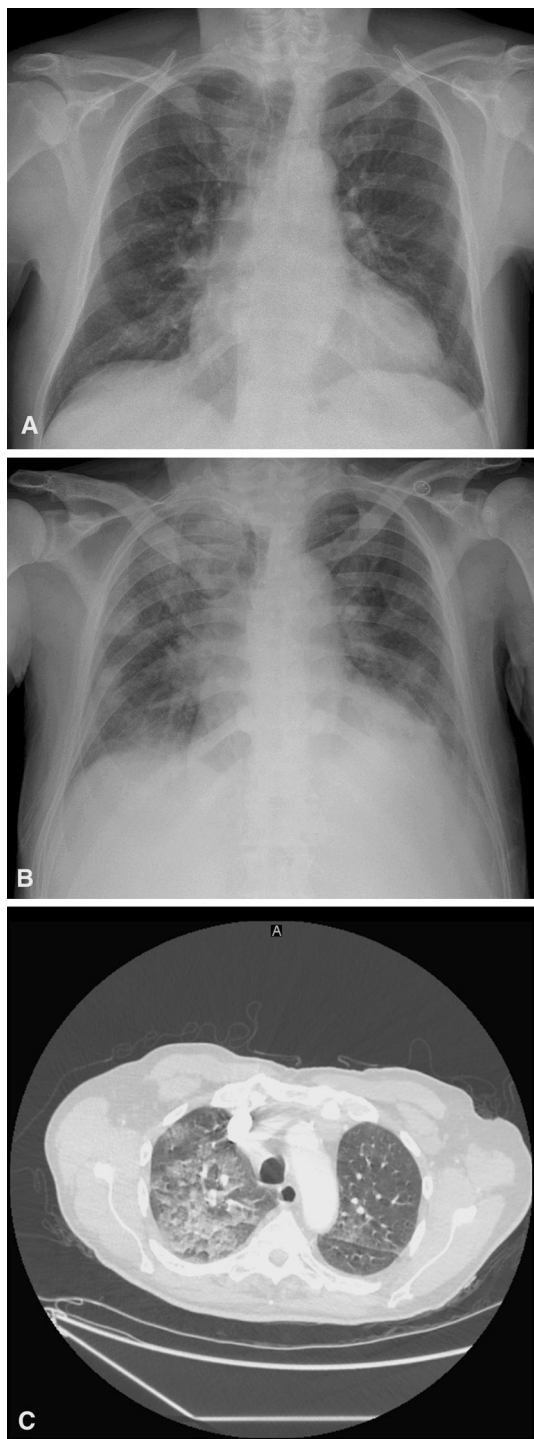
a Chest X-ray performed on the day of hospitalization. b Chest X-ray and c CT scan performed on the day of acute respiratory distress syndrome diagnosis with the presence of bilateral infiltrates and pleural effusion
